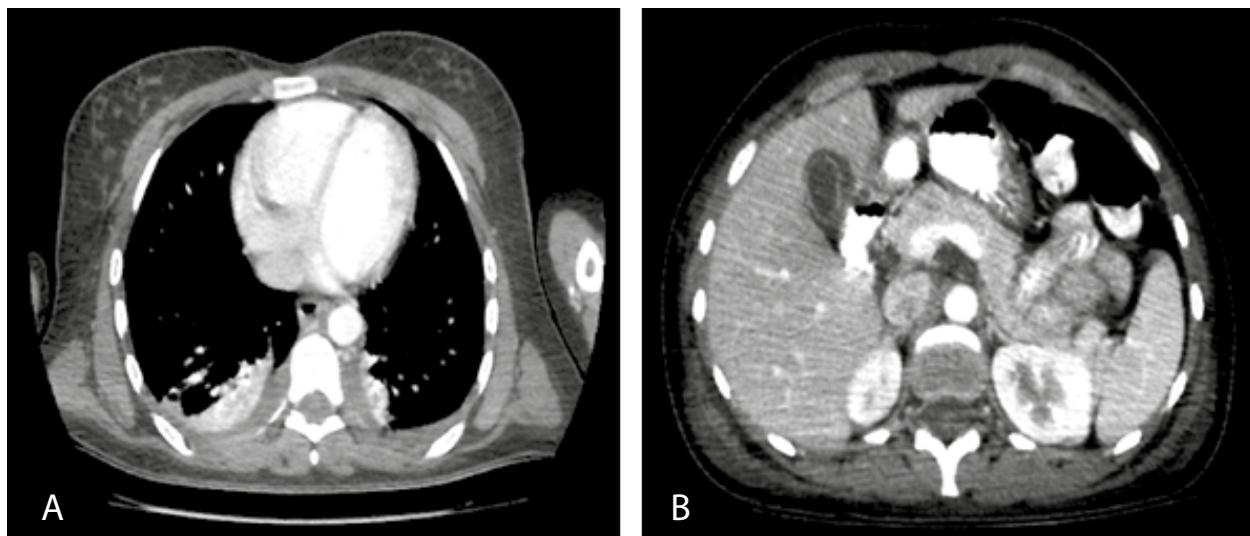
CT scans. A) Axial plane of the lungs showing pleural effusion associated with atelectasis; B) Axial plane of the abdomen with evidence of an inflammatory process in the gallbladder that is not associated with calculi.
